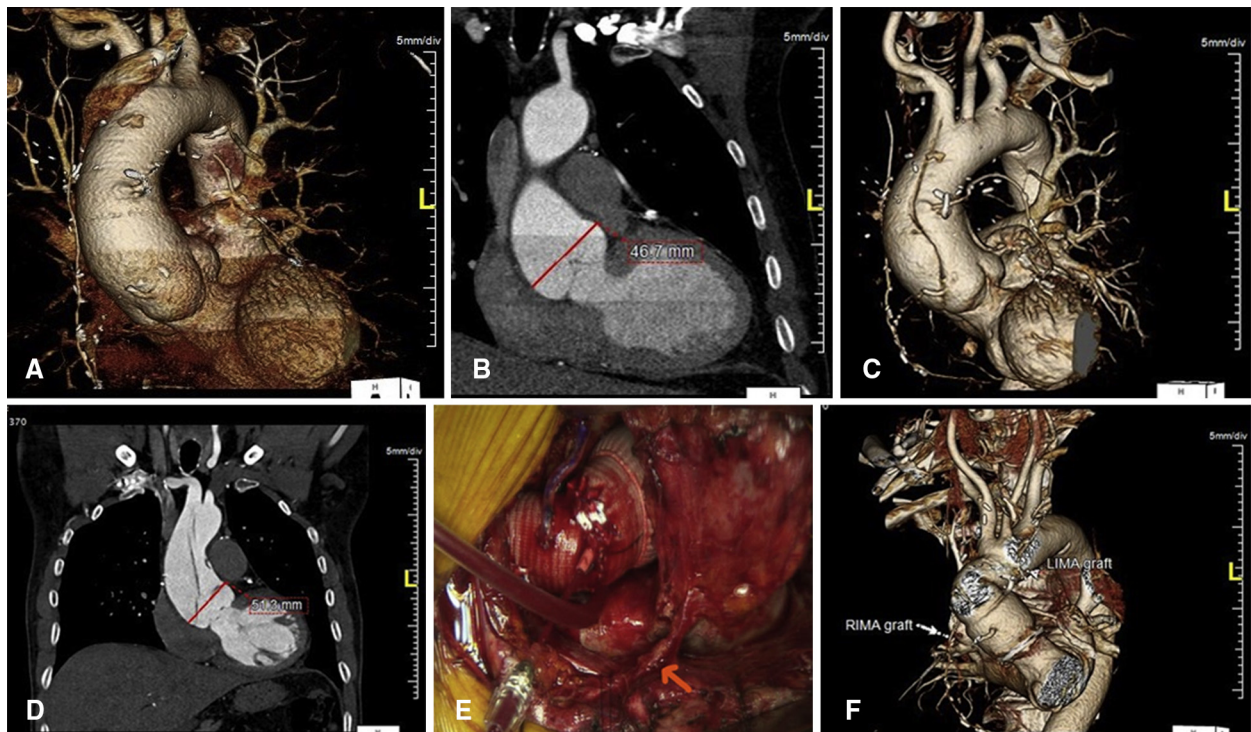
CTA and operative images from a 60-year-old male patient status-post previous coronary artery bypass grafting (including bilateral pedicled IMA grafts) 10 years earlier, who dissected under aortic surveillance with aortic dimensions not meeting criteria for surgical intervention. A, Routine surveillance 3D reconstruction CTA image done 2 months before the patient presented with an acute type A dissection. B, Coronal reconstruction image from same scan demonstrating 4.7-cm maximal aortic root diameter, which was stable from the previous year’s imaging and did not meet criteria for surgical intervention. C, 3D reconstruction image done 2 months later when the patient presented with an acute type A dissection. D, Coronal reconstruction image from same scan demonstrating increase in maximal aortic root diameter to 5.1 cm as a consequence of the dissection. E, Intraoperative photograph of completed bio-Bentall and hemiarch repair with saphenous vein graft extension to his previous radial arterial graft. Both pedicled IMA grafts were preserved (arrow indicates pedicled RIMA graft). F, Surveillance CTA 6 years postoperatively at which time the patient continues to do well clinically. RIMA, Right internal mammary artery; LIMA, left internal mammary artery.
